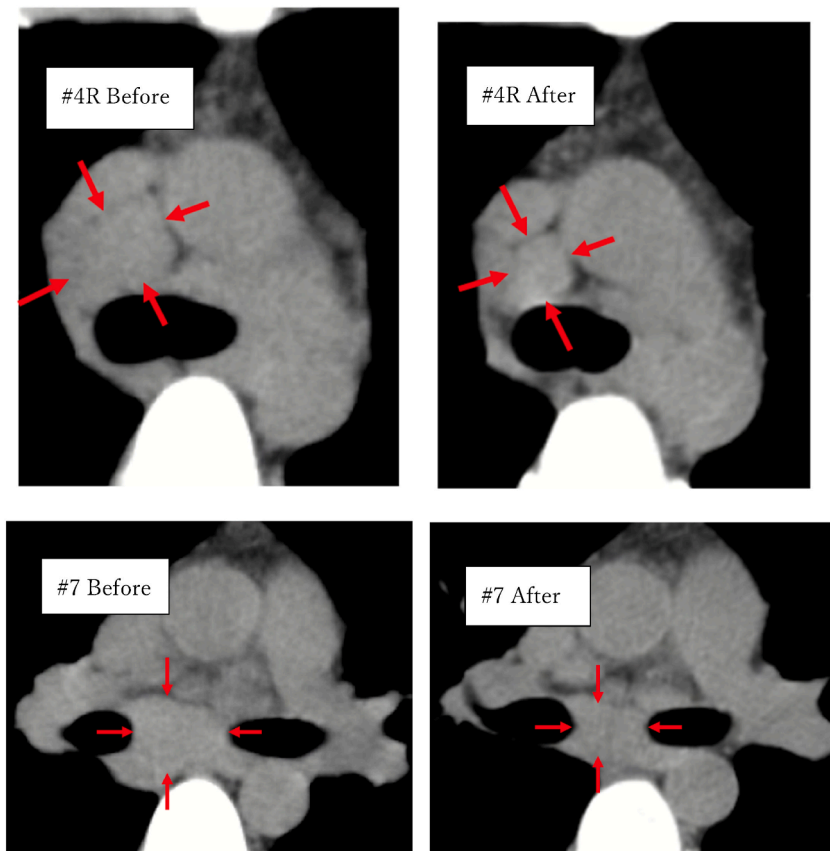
CT images before and after the cessation of dupilumab. Mediastinal lymphadenopathy (#4R and #7) before (left) and after (right) dupilumab cessation. Arrows indicate the lesions of lymphadenopathy.
